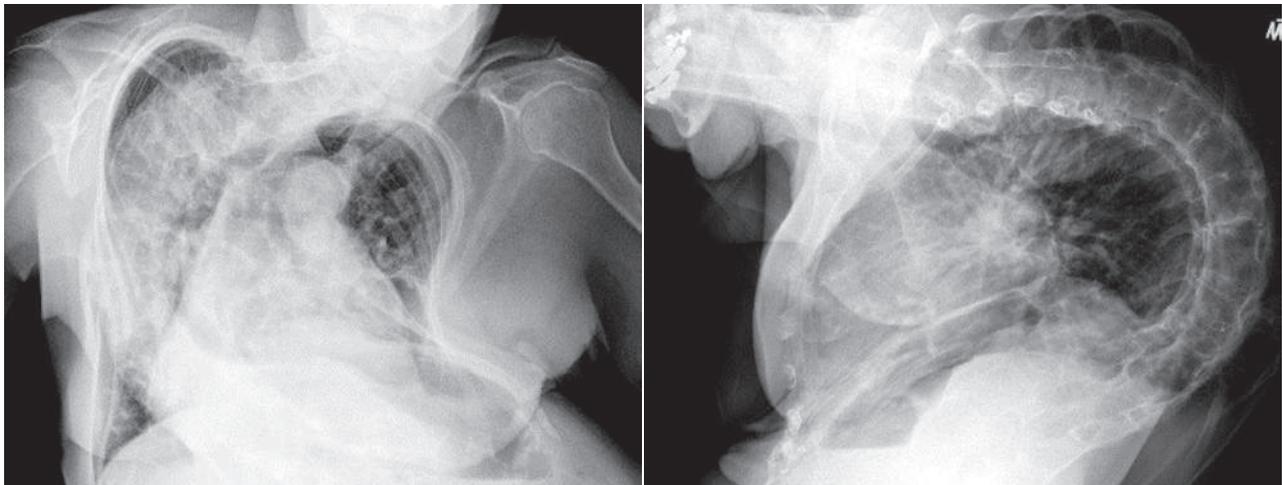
Frontal and lateral chest radiograph views of the same patient, showing severe scoliosis and kyphosis.
